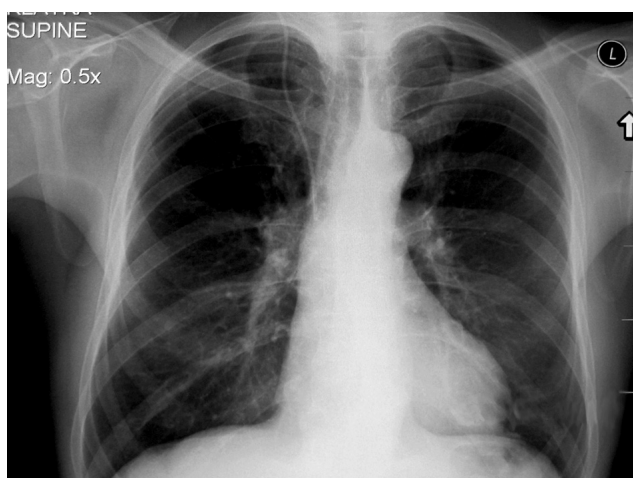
Preoperative chest X-ray shows position of the intravenous catheter and no signs of tumor of the right lung
